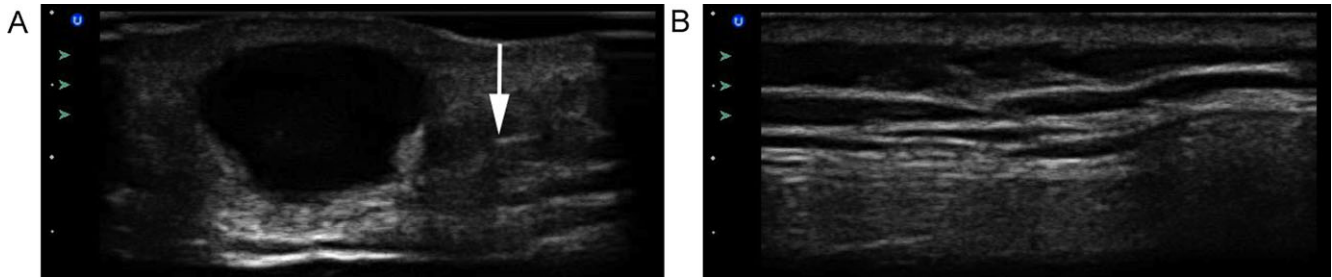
Soft tissue induration. There are two US images of an abscess cavity with surrounding induration (A) and images of the same patients contralateral normal soft tissue and no induration (B). Normal soft tissue is characterized by horizontal white lines parallel to the skin surface. The edge of induration can be visualized lateral (white arrow) and deep to the abscess cavity. US = ultrasound.
